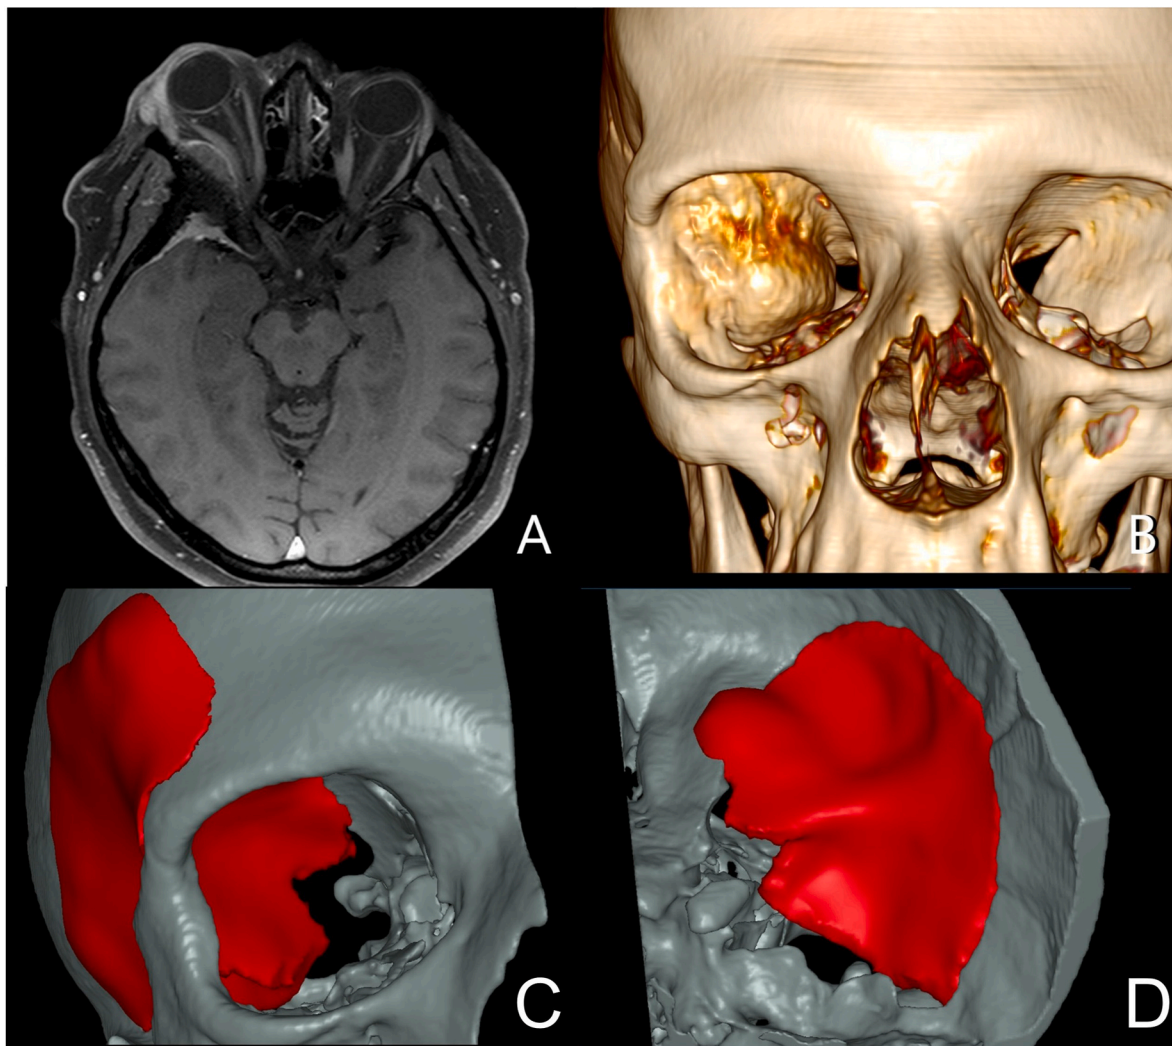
Patient 3. (A) Pre-op MRI showing hyperostotic area, intradural and intraorbital tumor components. (B) Pre-op 3D CT scan, frontal view, hyperostotic bone growing into the orbit is easily recognizable. (C, D) Post-op CT scan showing the position of the implant.
